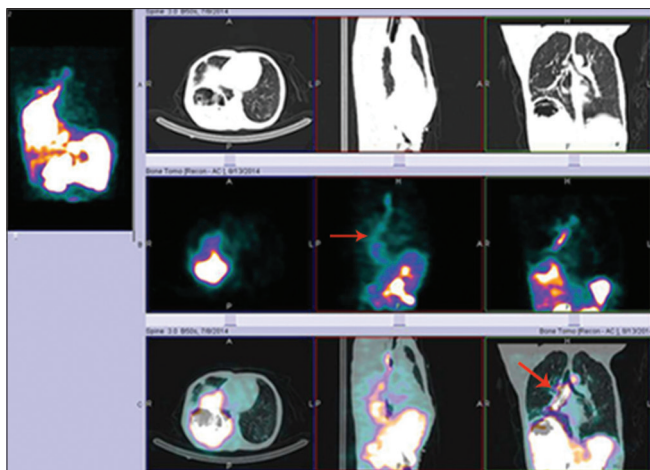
Hybrid single photon emission computed tomography/computed tomography images of thoracic and abdominal regions showing localization of tracer in the right subdiaphragmatic large collection with exact visualization of communication between right lower lobe bronchus and biliary system (arrows)
